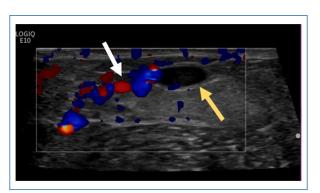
Grayscale ultrasound (US) at the left antecubital fossa in transverse and longitudinal views reveals a  $1.6 \times 0.5 \times 0.3$  cm serpentine, avascular, hypoechoic collection (yellow calipers) deep to the cephalic vein, which represents a small hematoma.
